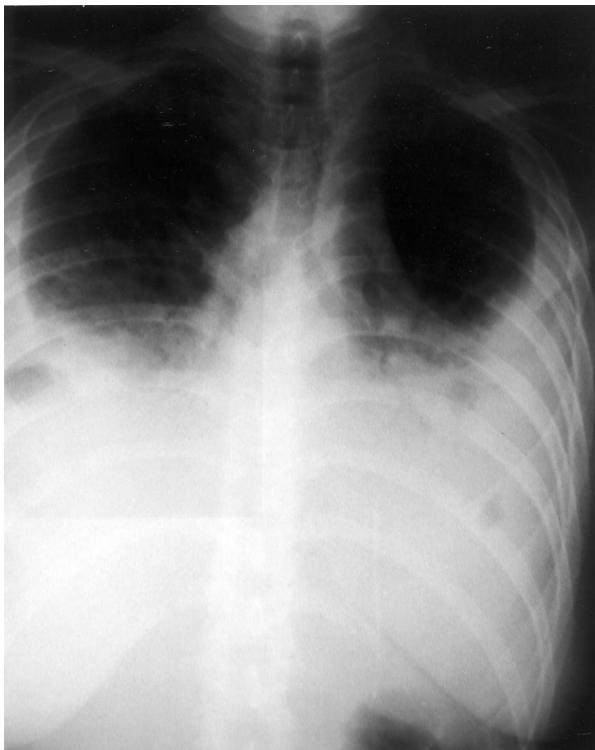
Chest radiograph showing bilateral pleural effusion with some interstitial and airspace opacities in the lower lobes, especially on the right.
